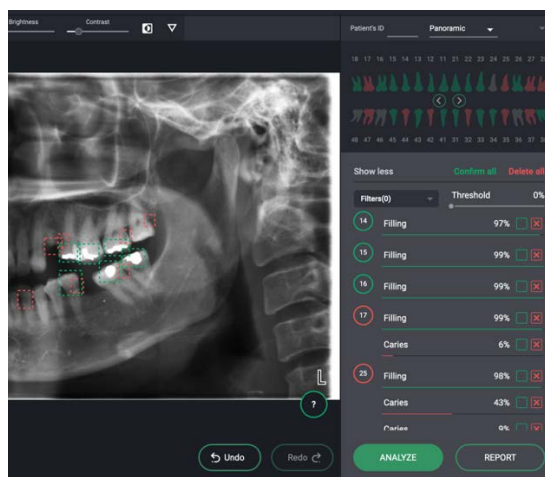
Panoramic radiograph analysis
